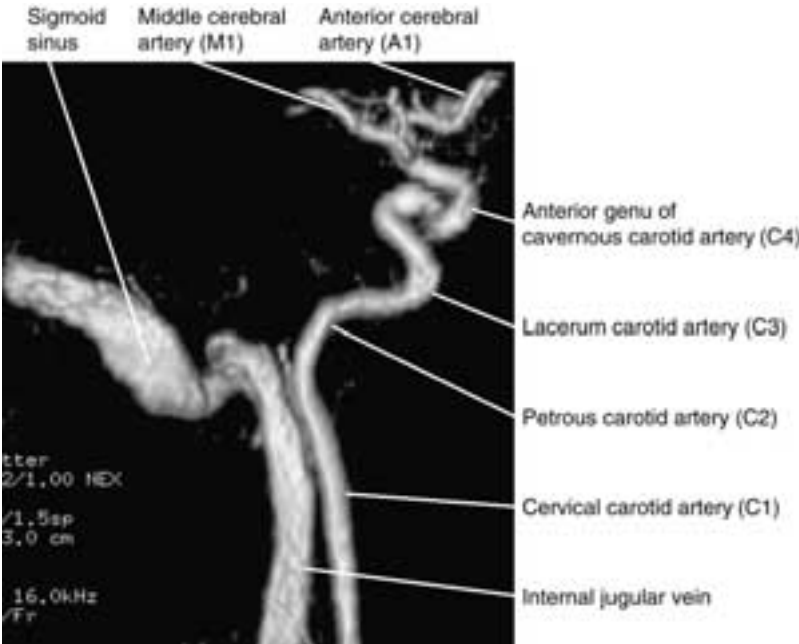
Two-dimensional time-of-flight MR imaging, lateral projection. The perspective is from the medial to lateral. The diverging carotid artery and jugular vein are well demonstrated. The jugular vein turns enter the sigmoid sinus.
